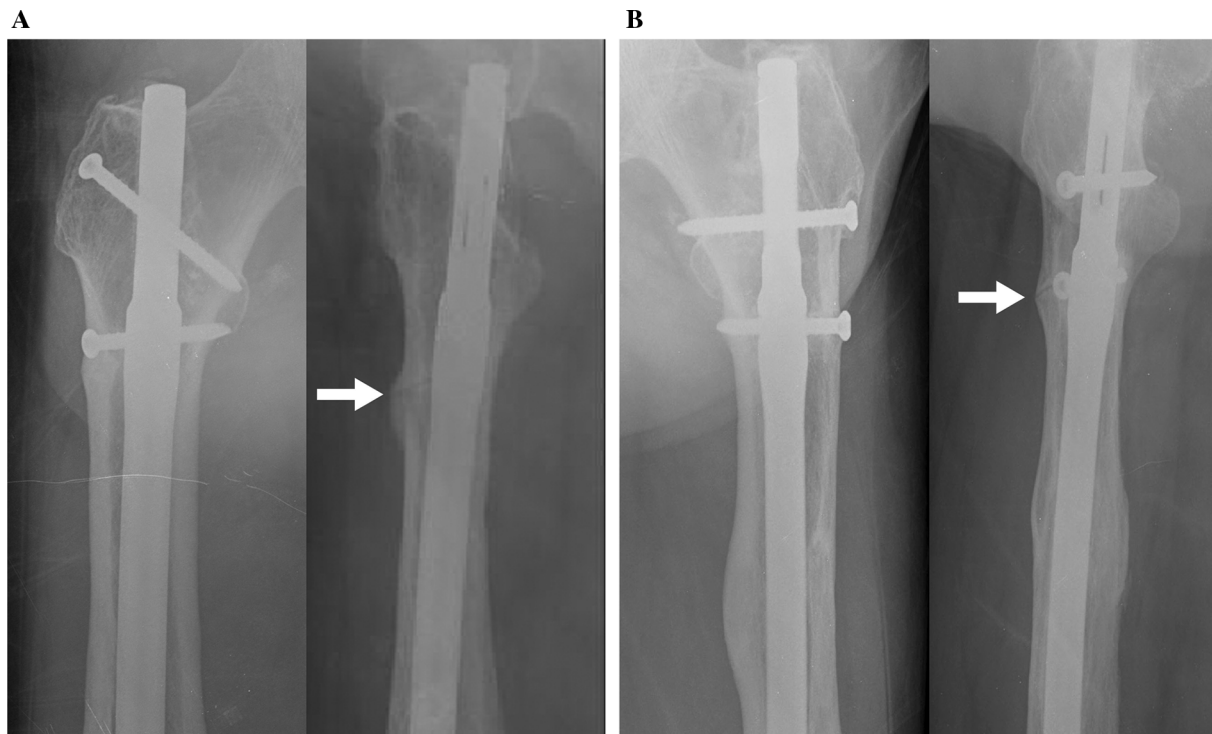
Follow-up both femur radiographs showed completely united both femoral shaft fracture, but radiolucent line with cortical hypertrophy at the anterior cortex near distal one of the proximal locking screws of the both femur (*arrow*). a Right. b Left
